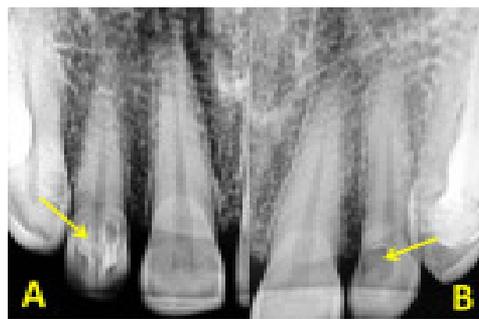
Radiographic appearance of 12 showing double dens invaginatus (A) & type I dens invaginatus w.r.t. 22 (B)
